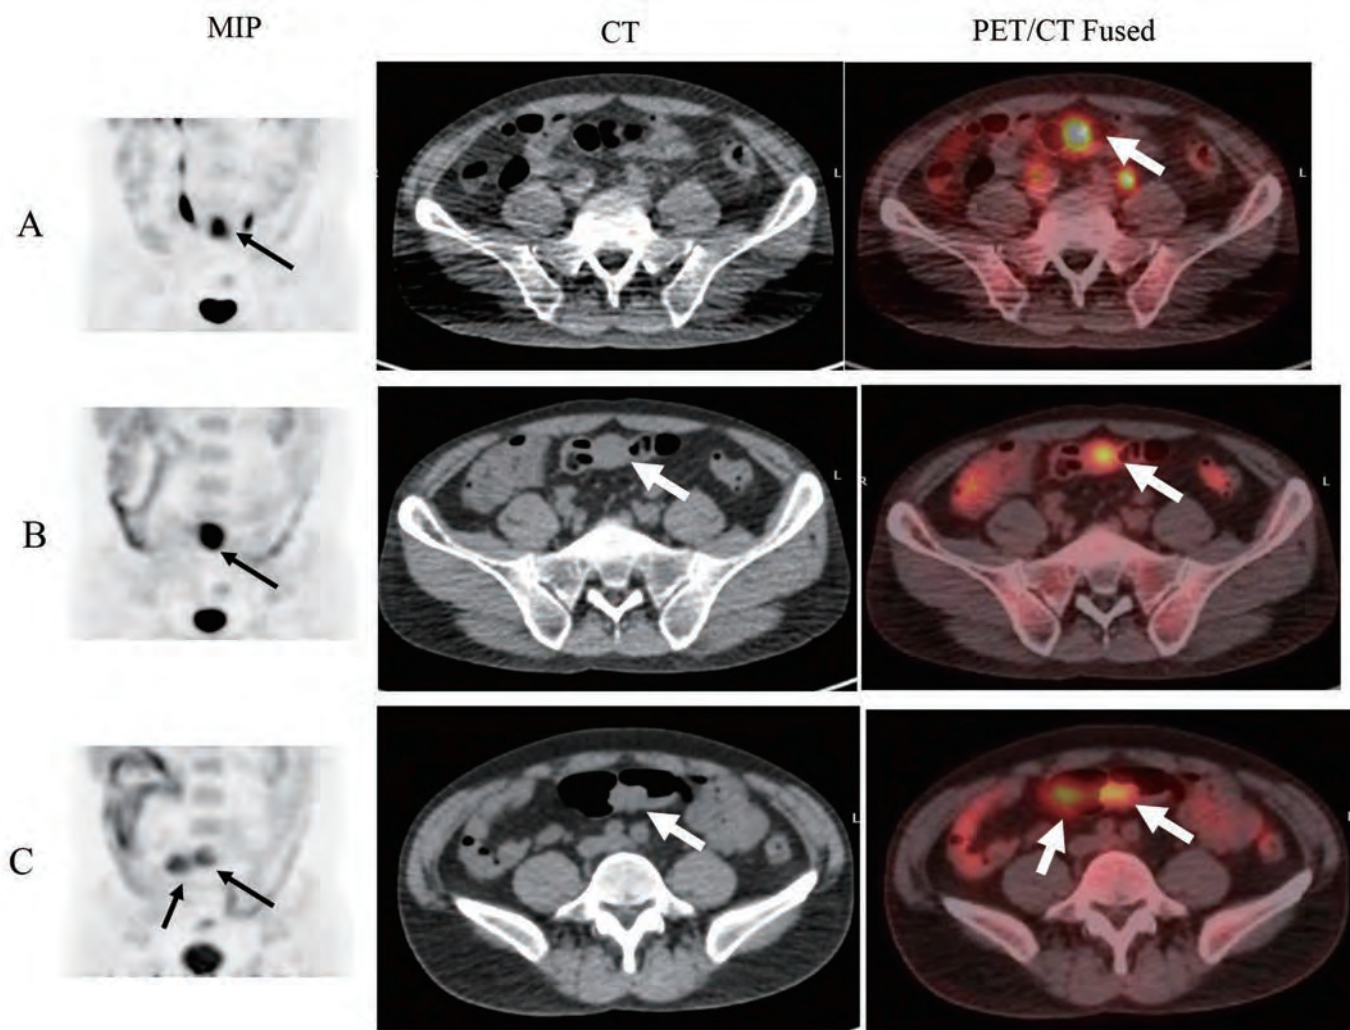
一個 58 歲男性食道癌病人 PET 的 MIP 和 CT 及 PET/CT Fused 影像，初期像 (A，左至右) 顯示腸道處有局部單一 FDG 攝取 (arrow)，延遲像 (B) 顯示 SUV 值增加 (6.15 升到 8.38，箭頭)，CT 上有一團軟組織，故再施行第二次局部延遲像 (C) 顯示原先局部病灶消散成二處且 SUV 值下降為 4.15 (箭頭)，故判讀為偽陽性。
